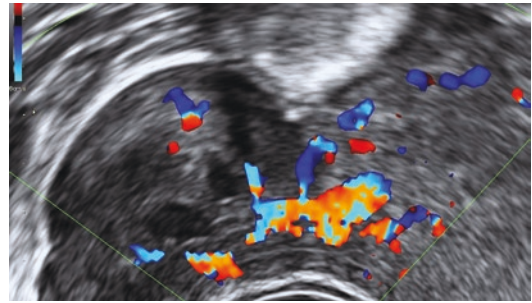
An ultrasound image of a pedunculated fibroid with a vascular pedicle demonstrated on Doppler assessment
